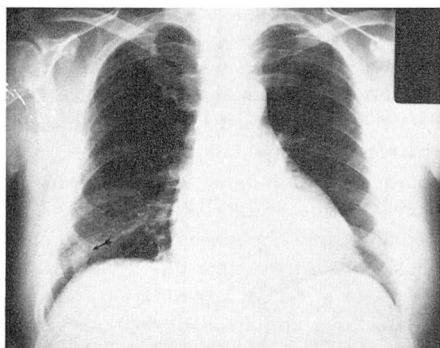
Roentgenogram showing coin lesion located near right hemidiaphragm (arrow).
